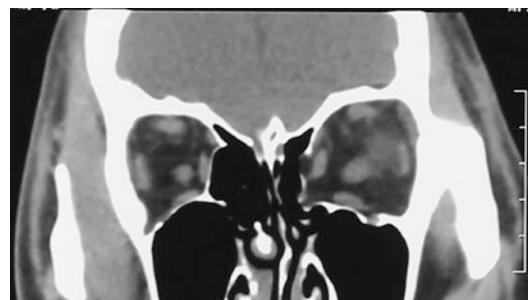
Orbital coronal CT showed that the left medial orbital wall was depressed by fracture, the corner was slightly displaced, and the medial rectus muscle and a small amount of adipose tissue were herniated into the ethmoid sinus
